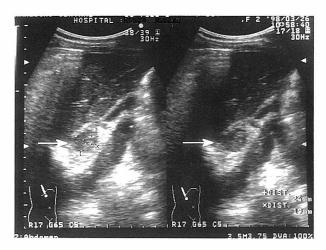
The mass lesion in the right adrenal gland was also detected by ultrasonography $(2.4 \text{ cm} \times 1.9 \text{ cm})$.
